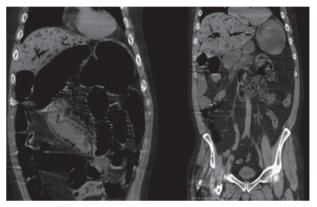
Abdominal-CT imaging showing pneumatosis intestinalis with presence of air bubbles in the superior mesenteric vein and concurrent intrahepatic portal air.
